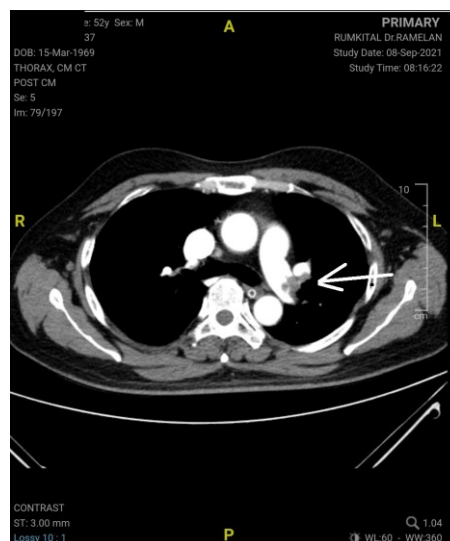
Chest CT Angiography.
